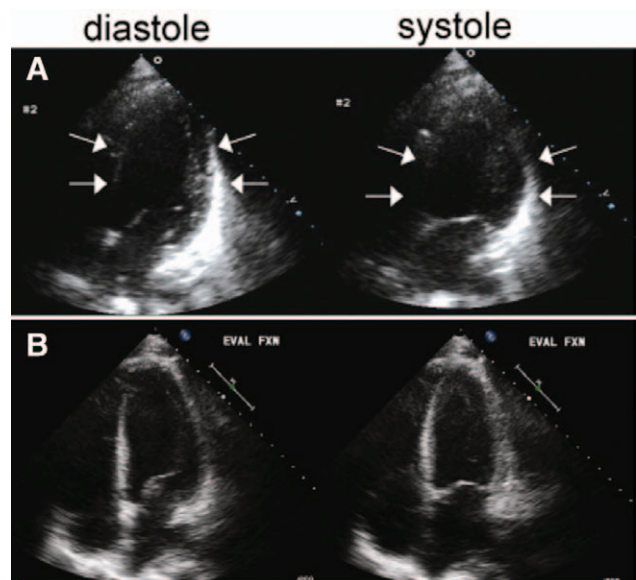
Echocardiogram of inverted neurogenic stunned myocardium. A, An apical view of the left ventricle shows basal ballooning during systole in the acute period. B, An apical view 13 days later shows recovery with uniform contraction of the left ventricle.
